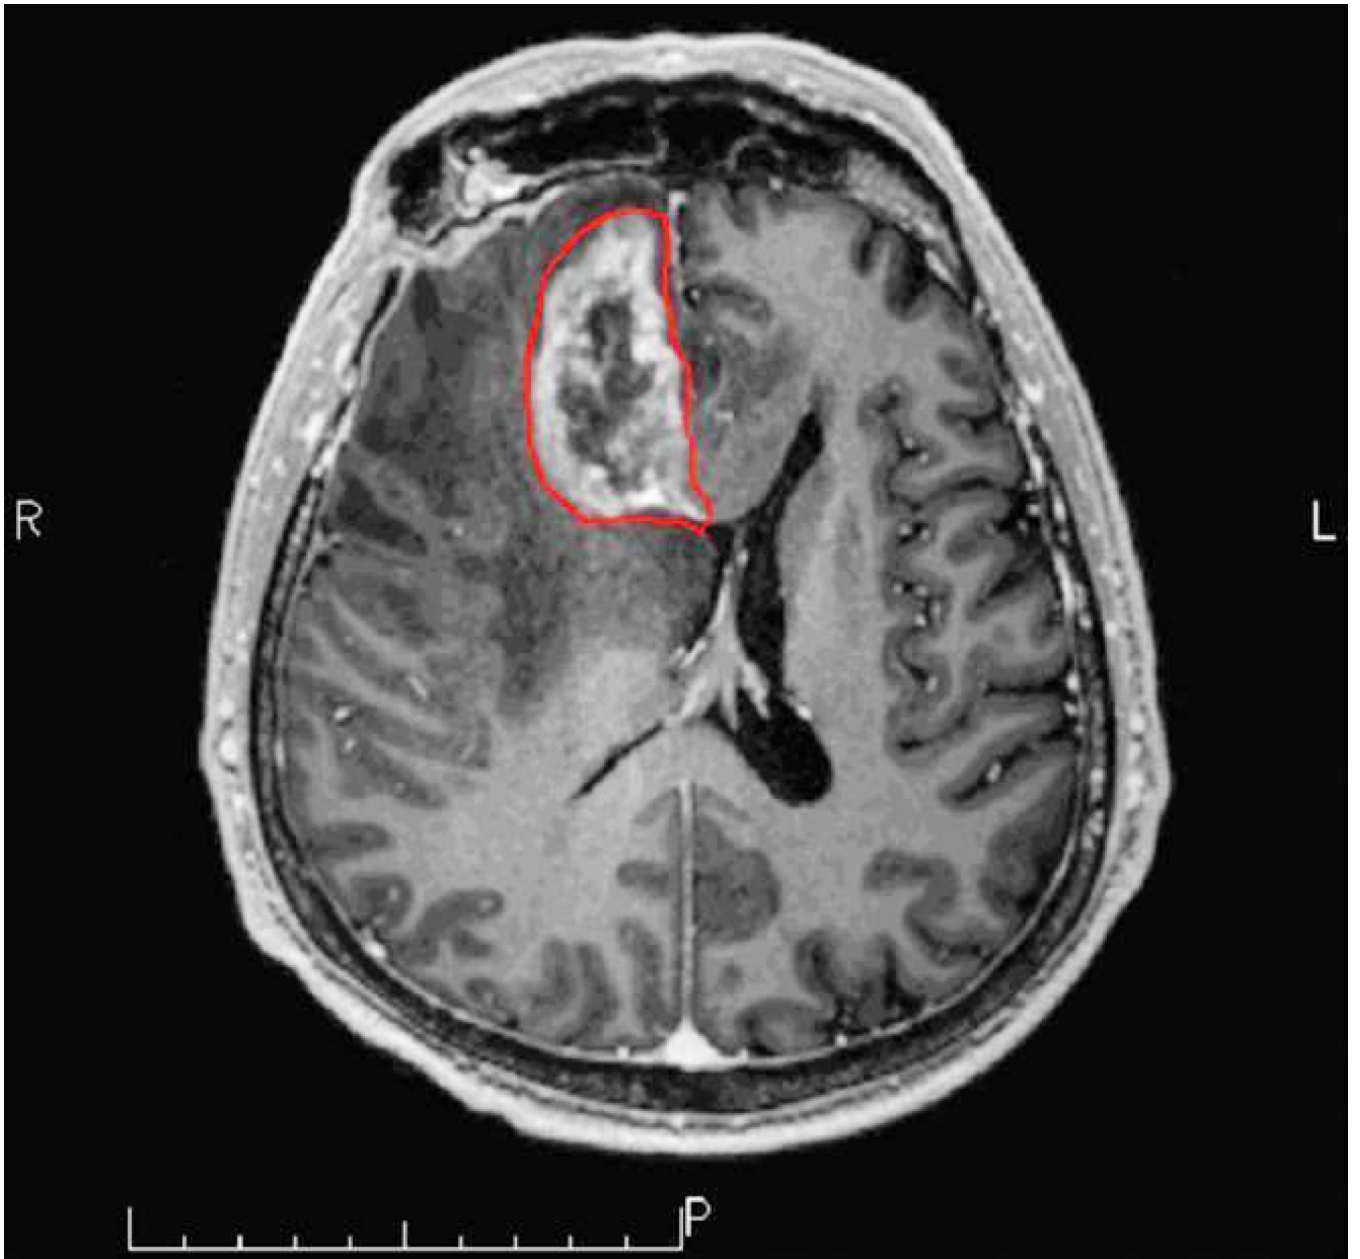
Axial post GD-DTPA T1-weighted image of Swiss-cheese appearance of contrast enhancement in a case of surgically proven radiation necrosis.
